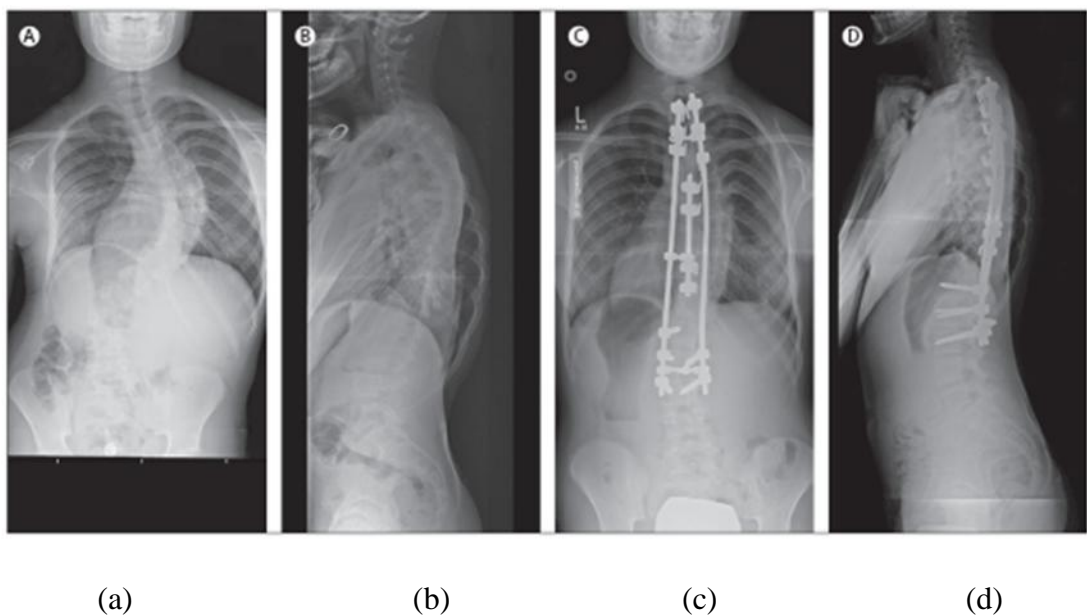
Radiographs of a teenager with progressive AIS treated by posterior instrumentation by hybrid (rods, hooks, and screws) (a) Preoperative standing posterior-anterior (PA); (b) preoperative standing lateral; (c) postoperative standing PA; and (d) postoperative standing lateral (Weinstein et al. 2008).
